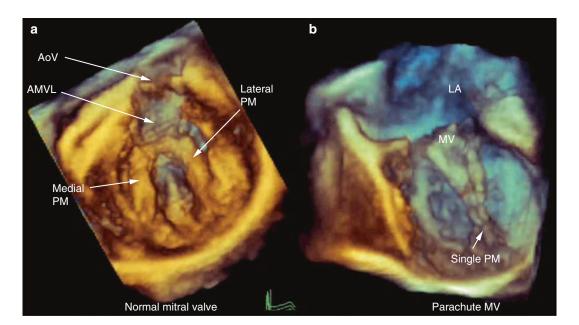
Normal and parachute mitral valves. 3D echocardiography is ideal for the assessment of congenitally abnormal atrioventricular valves. These 3D images are projected *en face* to the AMVL to show the chordal support. (a) This image shows a normal MV with two
